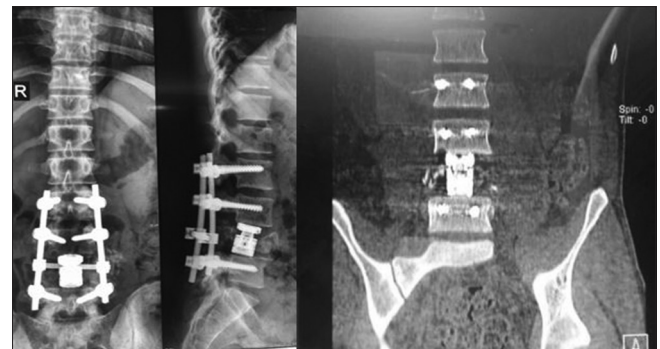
Two years postoperation computed tomography scan show good construct stability and solid bony fusion have been maintained with acceptable lumbar lordosis loss
